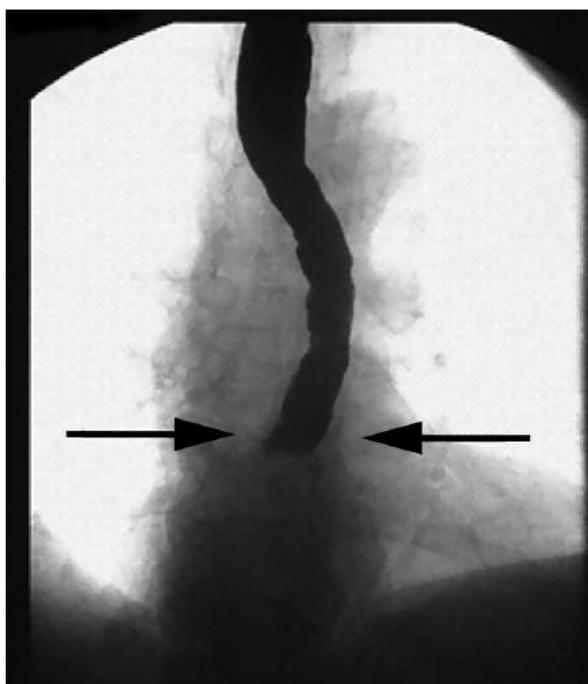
Food bolus in the lower third part of the oesophagus (oesophageal contrast radiography, from the collection of the author)
